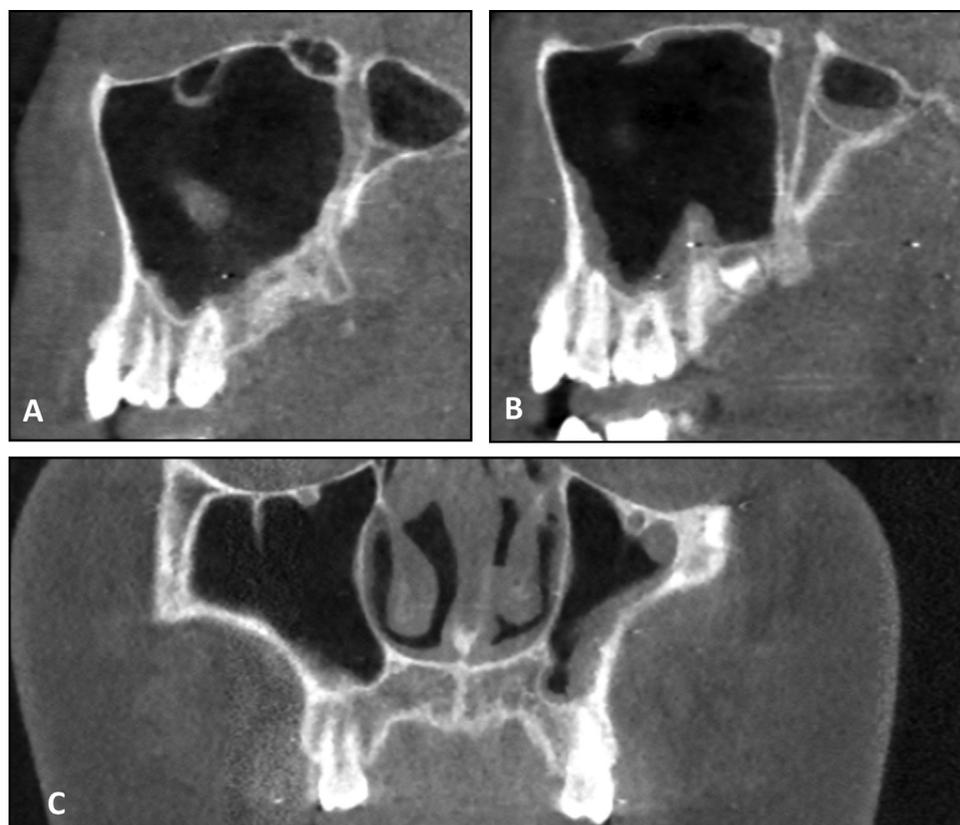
CBCT scans at 2 years' retention period. A, Autotransplanted right premolar shows sufficient vertical height and stability. B, On the left side, there remained sinusitis in the maxillary sinus. There is proximity between the apex of the transplant and the sinus floor. C, The coronal section showed good prognosis and stability (14 years 7 months age).
